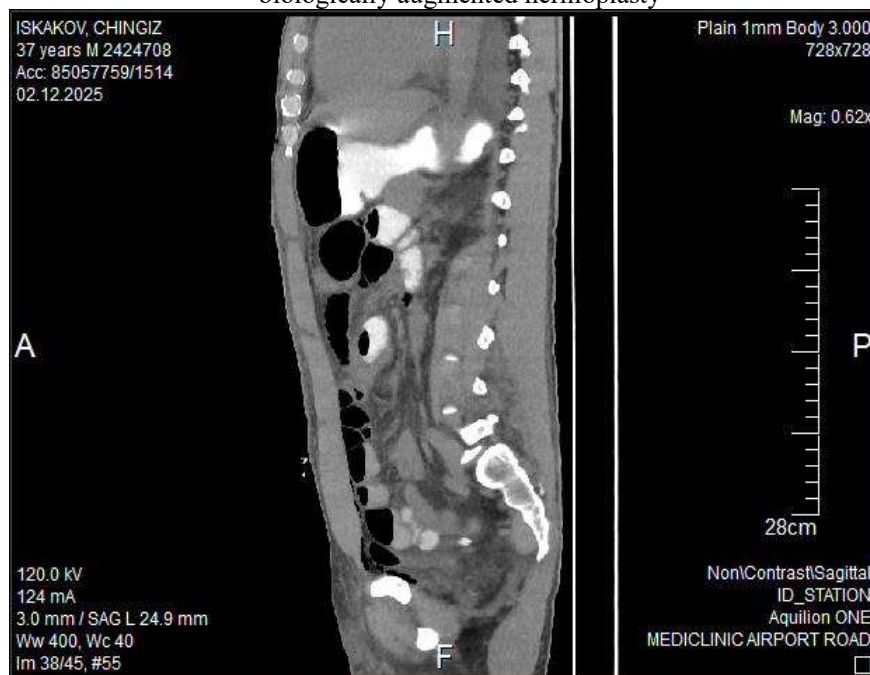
Sagittal reconstruction of the same post-operative CT (2 December 2025) showing dilated bowel loops in the central abdomen, the abdominal-wall closure intact, and the right-sided drain in situ along the para-spinal gutter.
